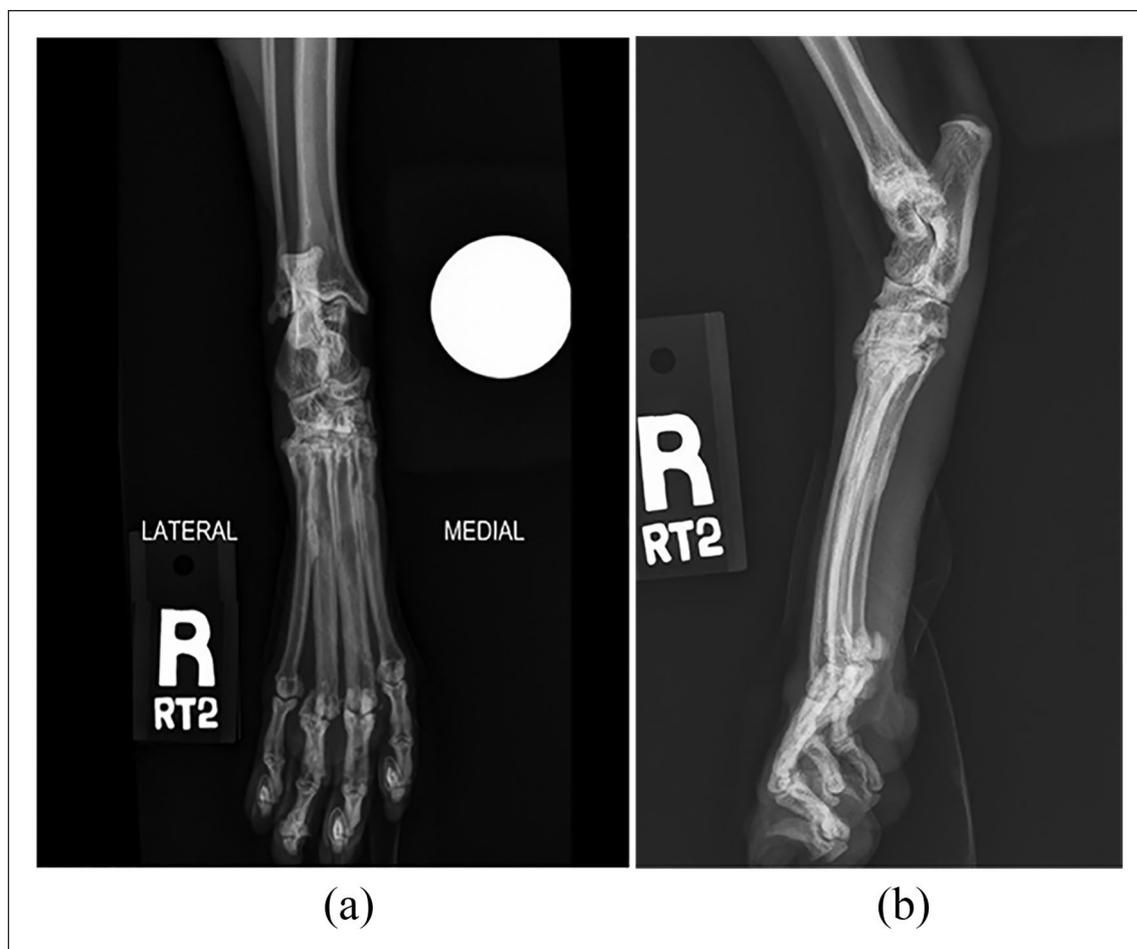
(a) Craniocaudal and (b) lateral radiographic images of the right pes obtained 6 months after surgery. There is moderate lateral displacement of the fourth metatarsophalangeal joint and both associated sesamoid bones, mild osteoarthritis of the third and fourth metatarsophalangeal joints, and moderate osteoarthritis of the tarsometatarsal and intertarsal joints
